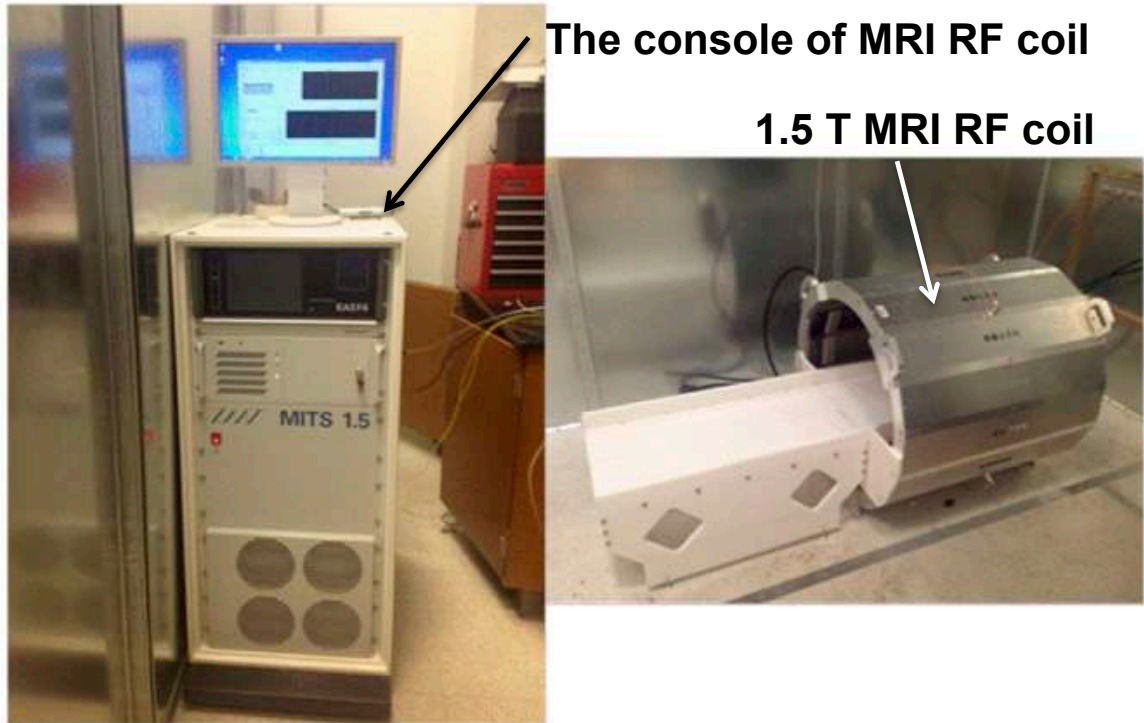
The 1.5 T MRI RF coil and the control console.
